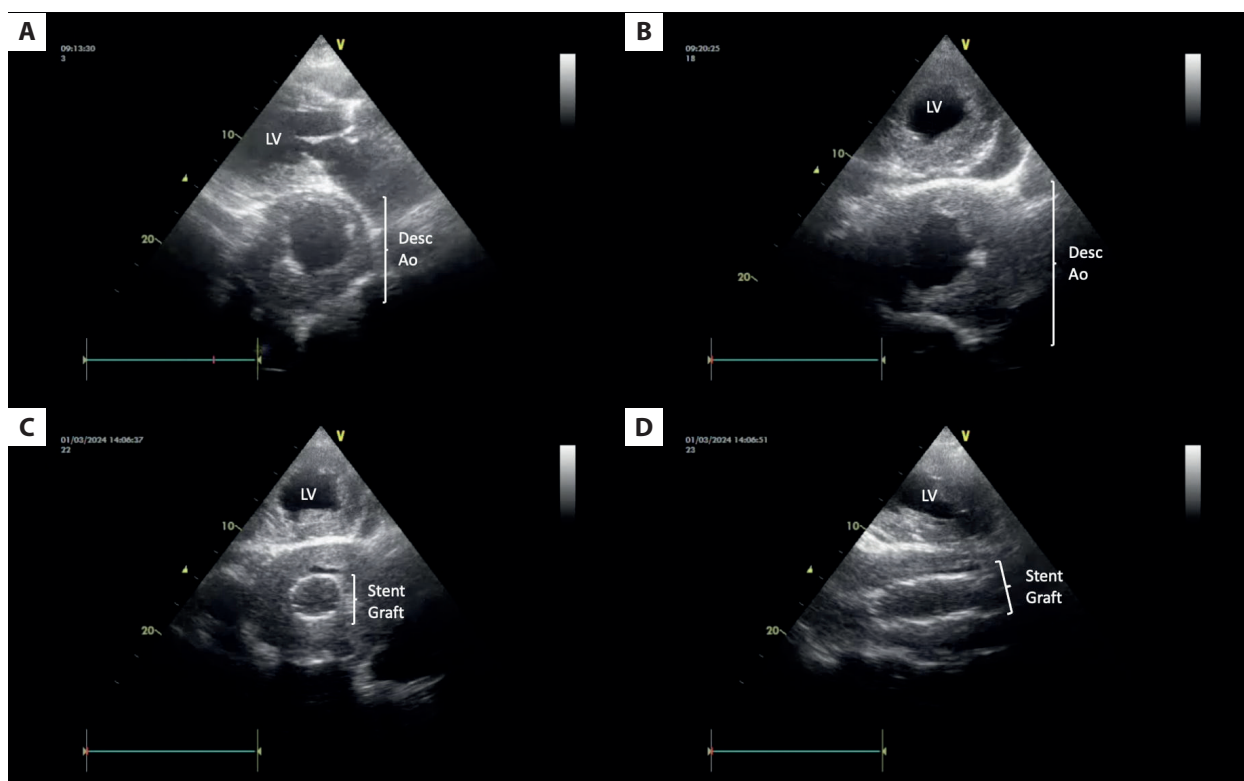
Echocardiography. Parasternal long (A) and short (B) axis view — before to surgery. Short axis view — after surgery (C). Modified 2 chamber view — after surgery (D)
